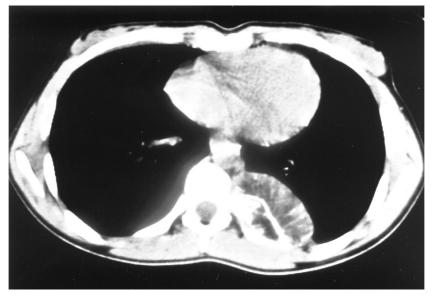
Chest CT shows coarsened trabecular pattern and the soft tissue mass accompanying the lesion.
